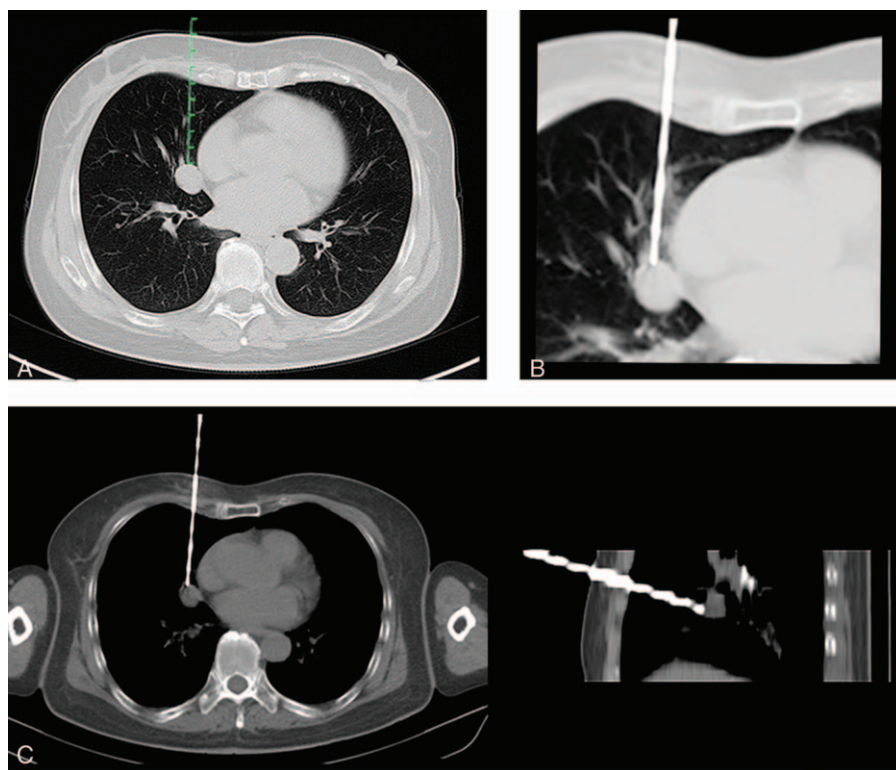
Hemorrhagic complication of CT-guided PTNB for a lesion in the right anterior region (region 3) in a 46-year-old female. A, CT image showed a 18 mm nodule attached to the right atrium in the right middle lobe. The needle path through the lung exceeded 5 cm and should have avoided injuring the pulmonary artery, vein, and bronchus of the middle lobe, which were identified clearly near the lesion. B, A 17-gauge introducer needle was inserted carefully, and biopsy was carried out with an 18-gauge semiautomatic cutting needle. C, CT showed intrapulmonary hemorrhage along the needle path. This patient presented mild hemoptysis after PTNB. CT = computed tomography, PTNB = percutaneous transthoracic needle biopsy.
